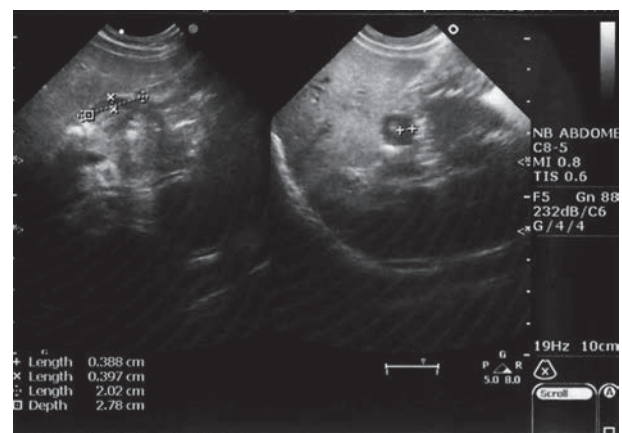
Abdominal ultrasonography of the patient revealed pyloric muscle thickness 3.97 mm and length 20.2mm, which is compatible to the diagnostic criteria of infantile hypertrophic pyloric stenosis.
